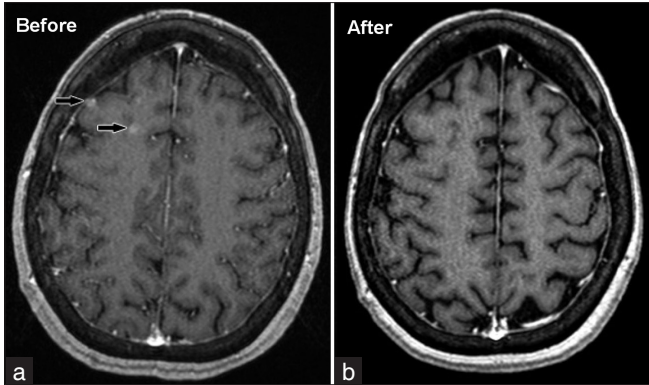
Magnetic Resonance Imaging of the brain before (a) and after erlotinib (b)
